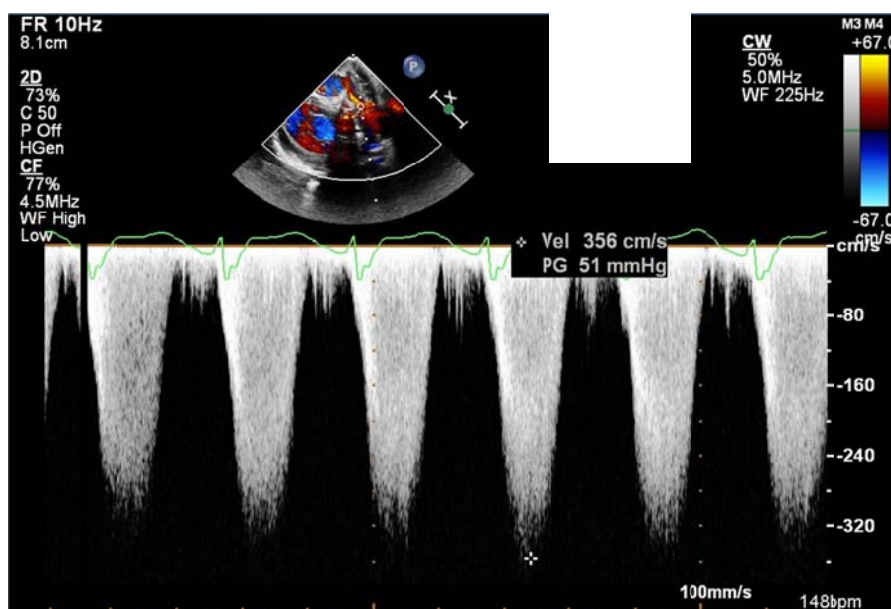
Transgastric Right ventricular outflow view & CW Doppler interrogation of the structure
